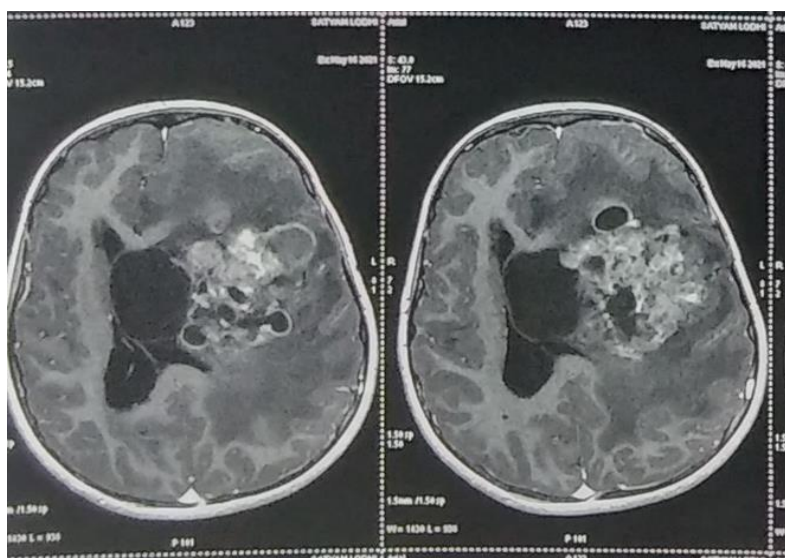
Preoperative MRI Scan
